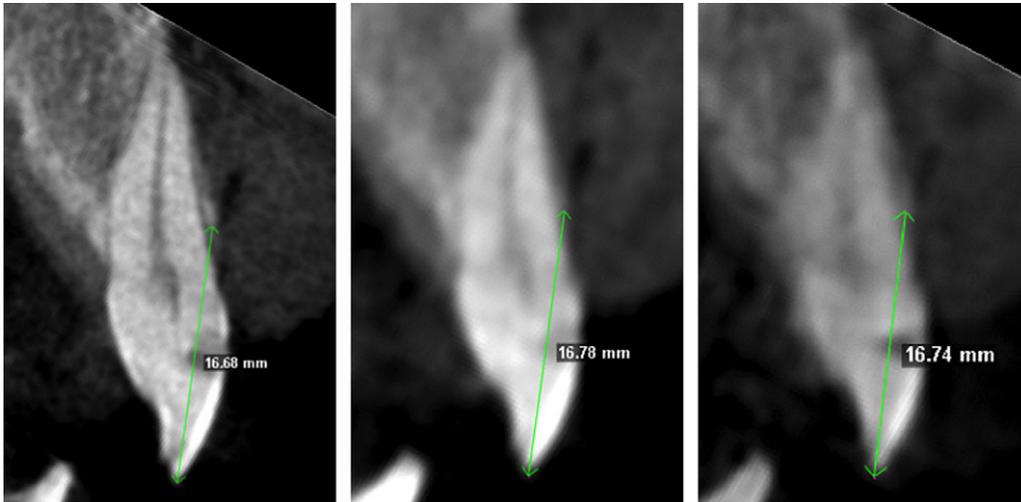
Example of buccal alveolar bone height (BBH) measurement from cone beam computed tomography (CBCT) sections using long scan (left), default scan (9; center), and short scan (right) CBCT acquisition settings.
